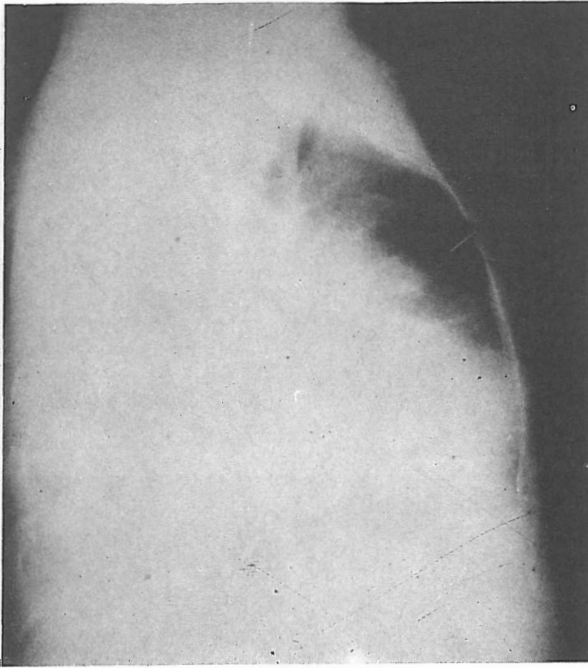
Chest x-ray of the patient demonstrating global cardiomegaly, most likely due to massive pericardial effusion.
